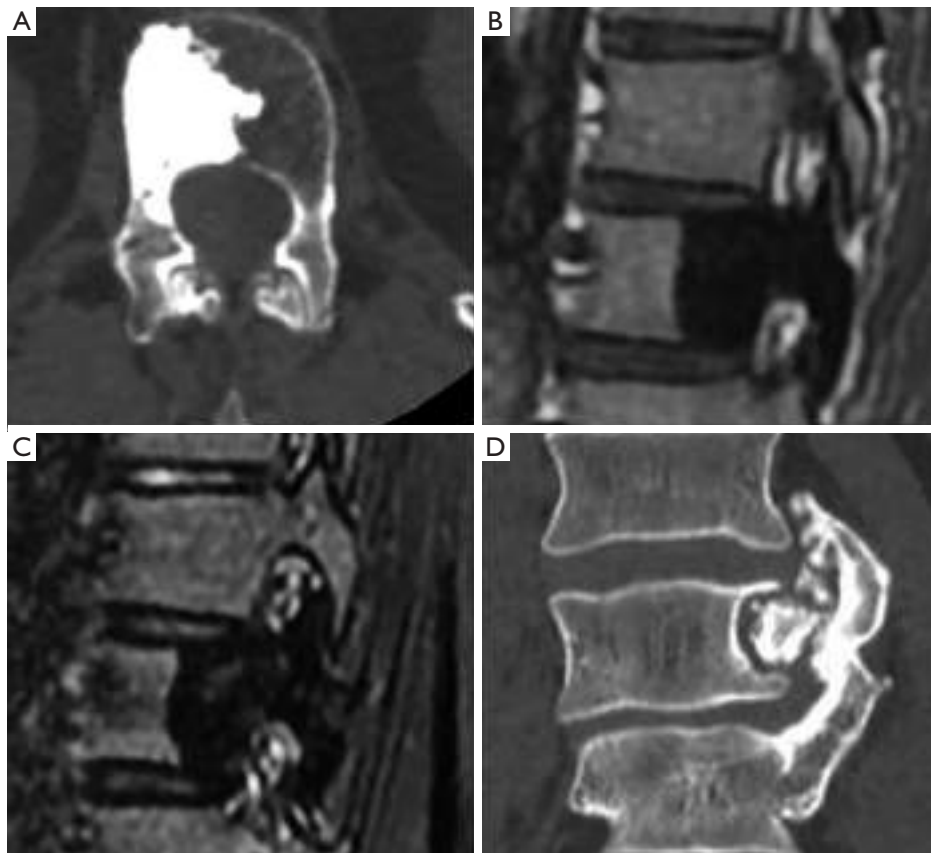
Benign tumors of the spine. (A) Axial CT image of enostoma; (B) sagittal T1 and STIR (C) images of enostoma; (D) coronal reformatted CT image of osteochondroma. CT, computed tomography; STIR, short tau inversion recovery.
